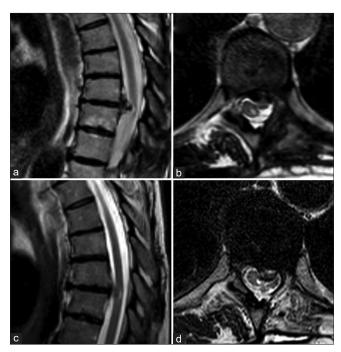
(a) 2015 Thoracic column magnetic resonance imaging (MRI) in median sagittal T2-weighted sequence, (b) T8–T9 axial T2-weighted sequence, (c) 2017 Thoracic column MRI in median sagittal T2-weighted sequence, and (d) T8–T9 axial T2-weighted sequence. Follow-up MRI scans demonstrated the stability of the residual calcific disc herniation in time.
